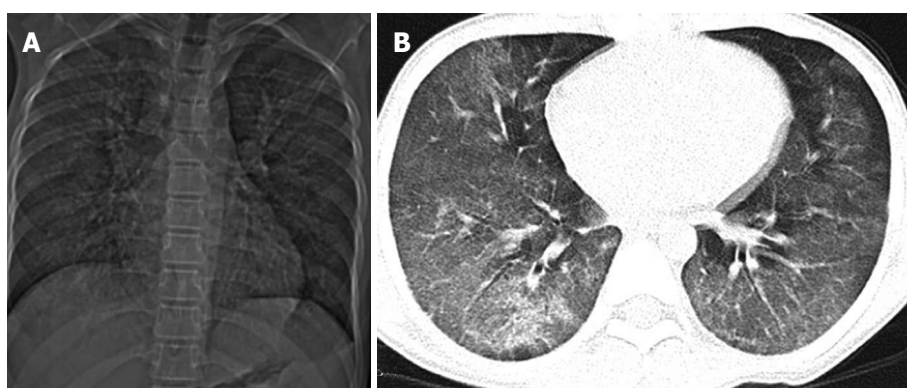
A 15-year-old boy with idiopathic pulmonary hemosiderosis. Scout computed tomography (CT) image (A) and axial CT image (B) showing diffuse ground glass opacity in bilateral lungs.
